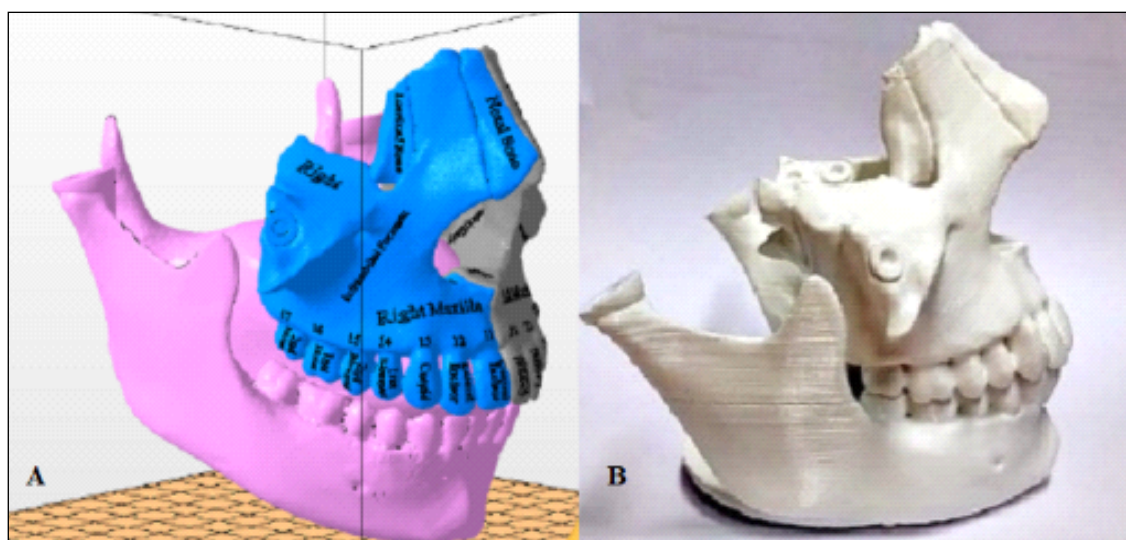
3D prototypes of the patient's jaws based on CBCT scans of the skull (A), 3D prototypes of the jaws printed on a 3D printer (B)
